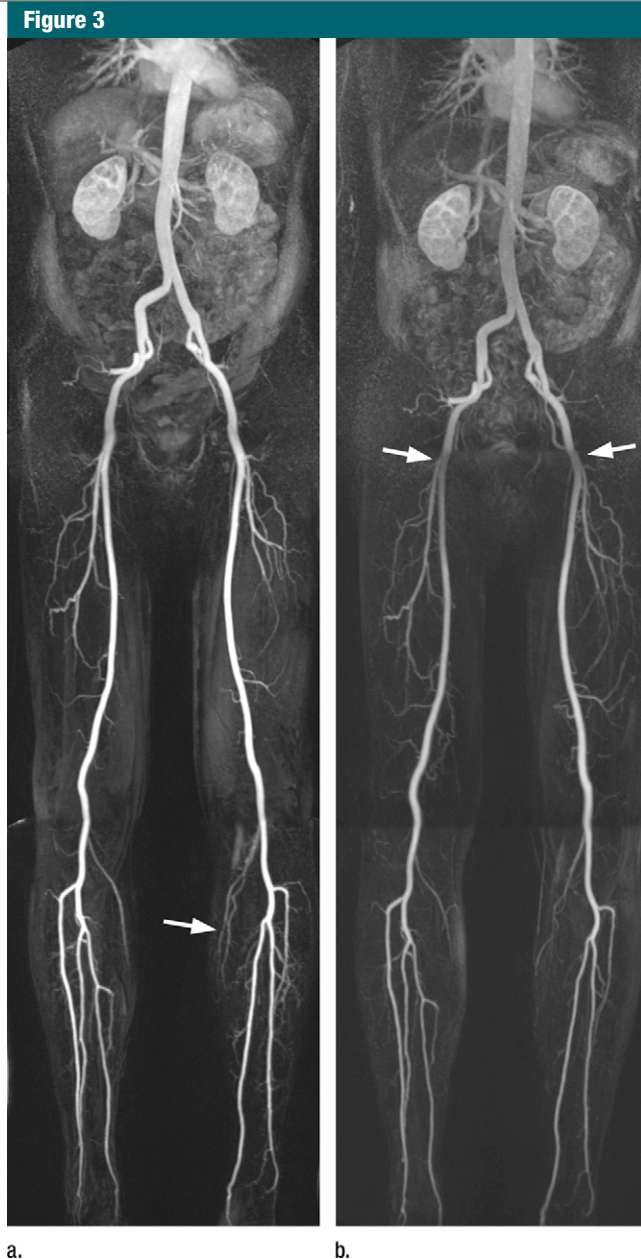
MR images (3.0/1.1; flip angle, 25° [pelvis]; 2.9/1.0; flip angle, 25° [thigh]; and 3.0/1.1; 25° [calf]) in 68-year-old man show moderate claudication in right and left calf (Fontaine stage IIb) after administration of 0.1 mmol/kg of (a) gadobenate dimeglumine, and (b) gadopentetate dimeglumine. Although on-site investigators considered quality of vessel visualization as excellent across all territories in both limbs for both agents, contrast enhancement obtained with gadobenate dimeglumine is much more homogeneous, with no decrease of signal intensity at boundaries between acquisition steps (arrows, b). Also, small vessels are more clearly seen with gadobenate dimeglumine, with better depiction of small arteries in popliteal area (arrow, a).
